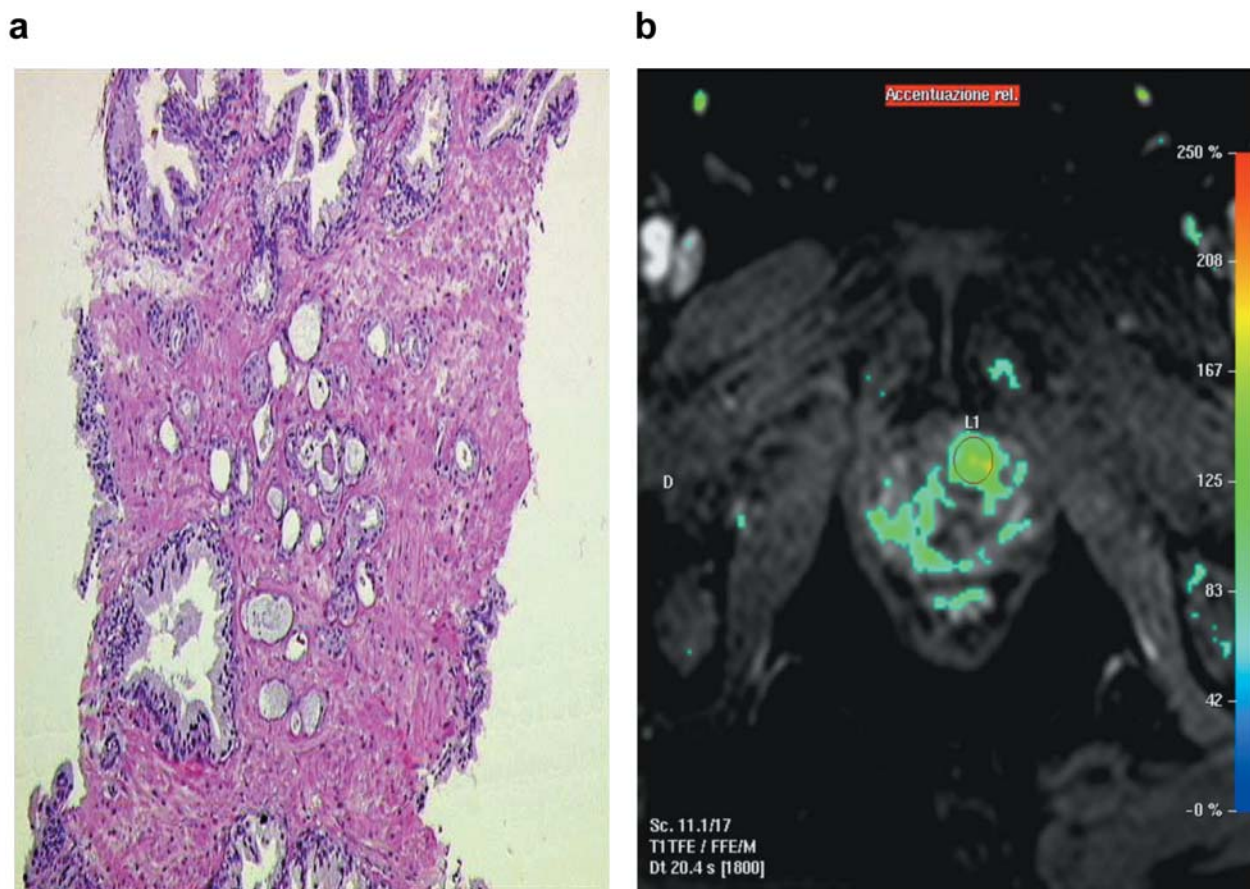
A 67-year-old man with an initial biopsy showing a microfocal of prostate cancer (a) submitted to multi-parametric pelvic MRI (b) that demonstrated a lesion (diameter of 12 mm) suspicious for cancer of the anterior zone of the gland. MRI-targeted biopsy detected 3 cores of Gleason score 6 with a greatest percentage of cancer equal to 50%.
